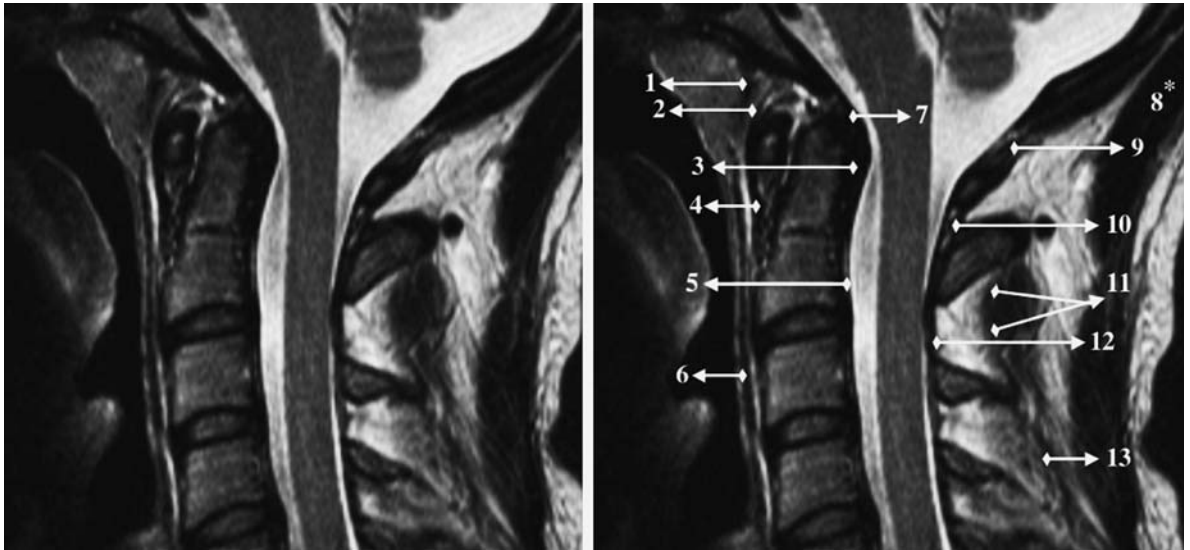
Normal ligamentous MR anatomy. Sagittal T2-weighted MR image obtained on 1.5-T. 1, Anterior atlanto-occipital membrane; 2, apical odontoid ligament; 3, transverse (cruciform) ligament; 4, anterior atlanto-axial ligament; 5, posterior longitudinal ligament; 6, anterior longitudinal ligament; 7, tectorial membrane; 8, nuchal ligament; 9, posterior atlanto-occipital membrane; 10, posterior atlanto-axial ligament; 11, interspinous ligaments; 12, flaval ligaments; 13, supraspinous ligament
